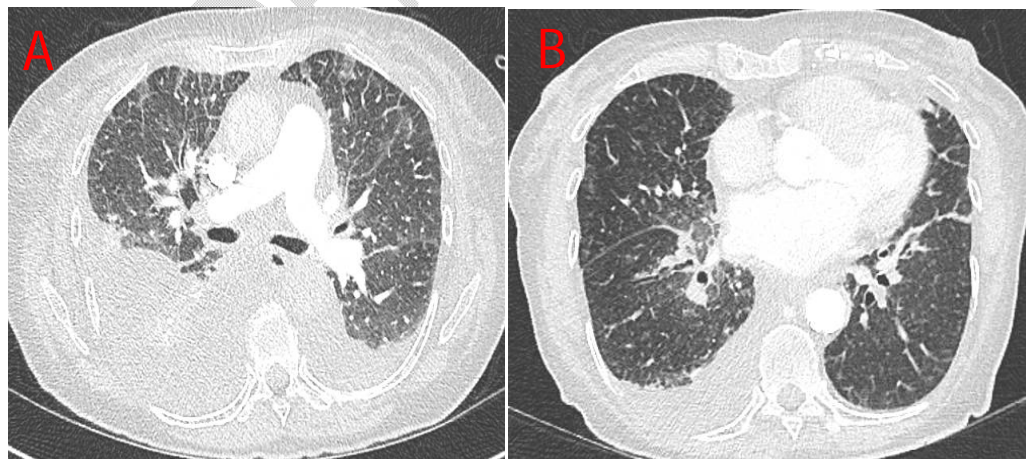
computed tomography chest scan (CT scan): A- Beforepleural puncture, showing abundant bilateral pleural effusion and alveolo-interstitial syndrome with thickening interlobular septa (lung fibrosis) and adenomegaly.
